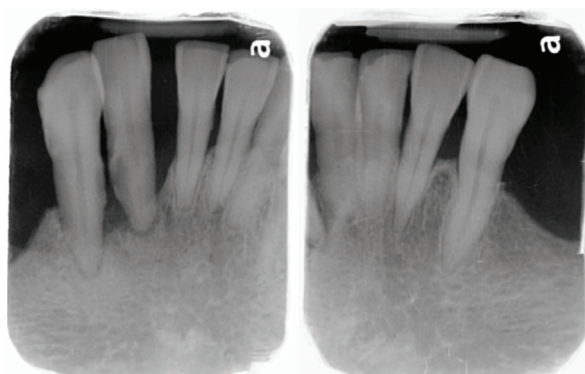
Pre-treatment periapical films.
